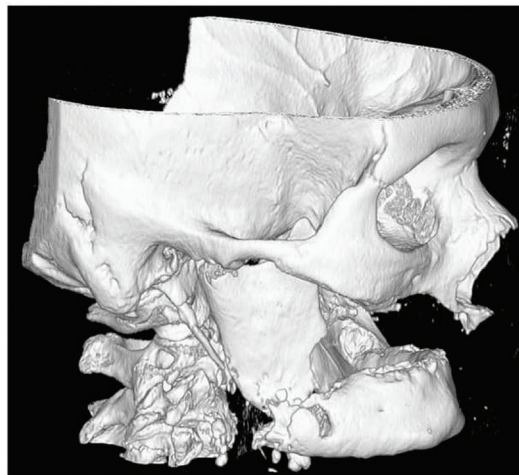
Three-dimensional computed tomography reconstruction of the head. Radiological image shows a noticeable pathological fracture of right jaw in a 69-year-old woman with breast cancer history and treated with zoledronic acid.
